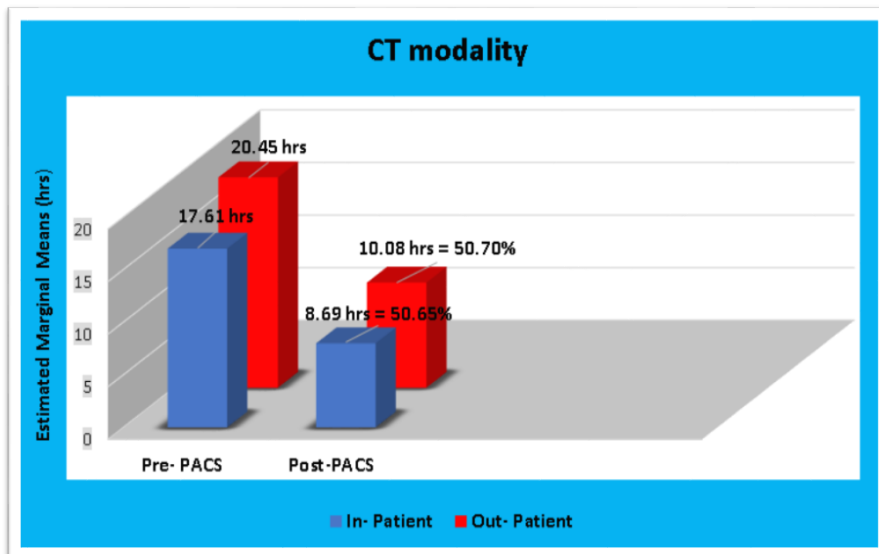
Estimated marginal means (hours & percentage) of report TAT for the CT modality
